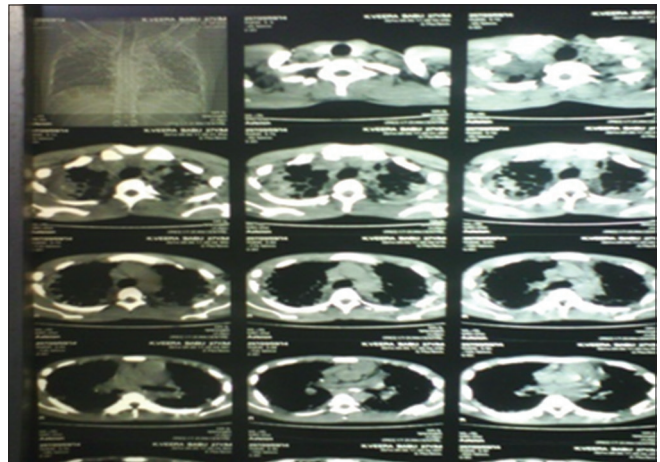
Computed tomography thorax: Bilateral multiple interstitial mottling with fibrosis
